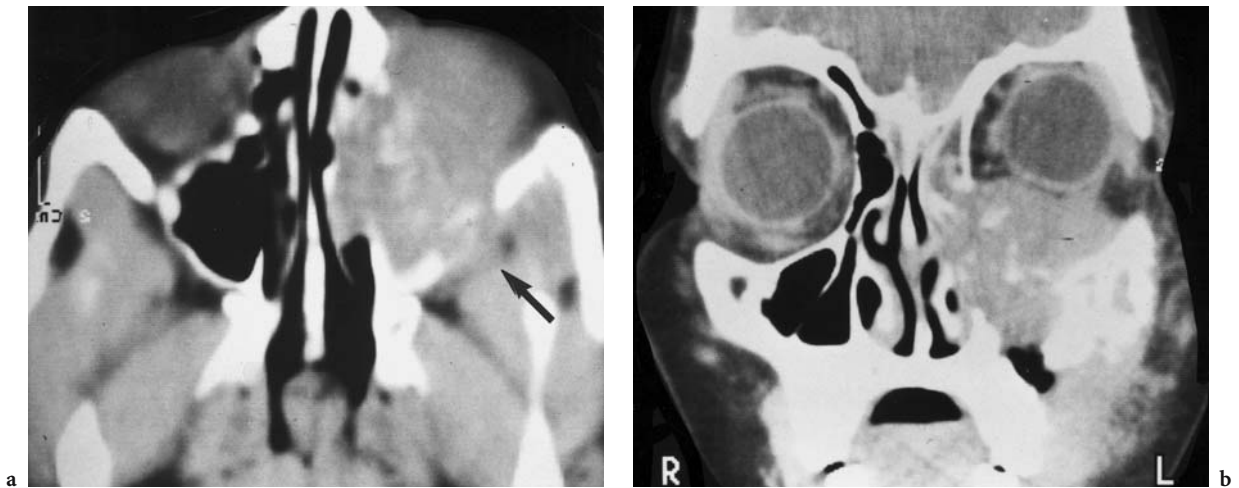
A 10-year-old girl with persistent swelling of the left cheek. Diagnosis: neuroblastoma. CT: a axial image, showing tumor invasion of the left maxillary sinus, ipsilateral retromaxillary (*arrow*), and nasal space with bone destruction. b Coronal view with upper globe displacement due to intraorbital tumor expansion with suspected infiltration of the external inferior muscle. Tumor growth probably started in the left upper maxillary sinus roof, destroying the maxillary and nasal bone and also invading the ipsilateral ethmoid
